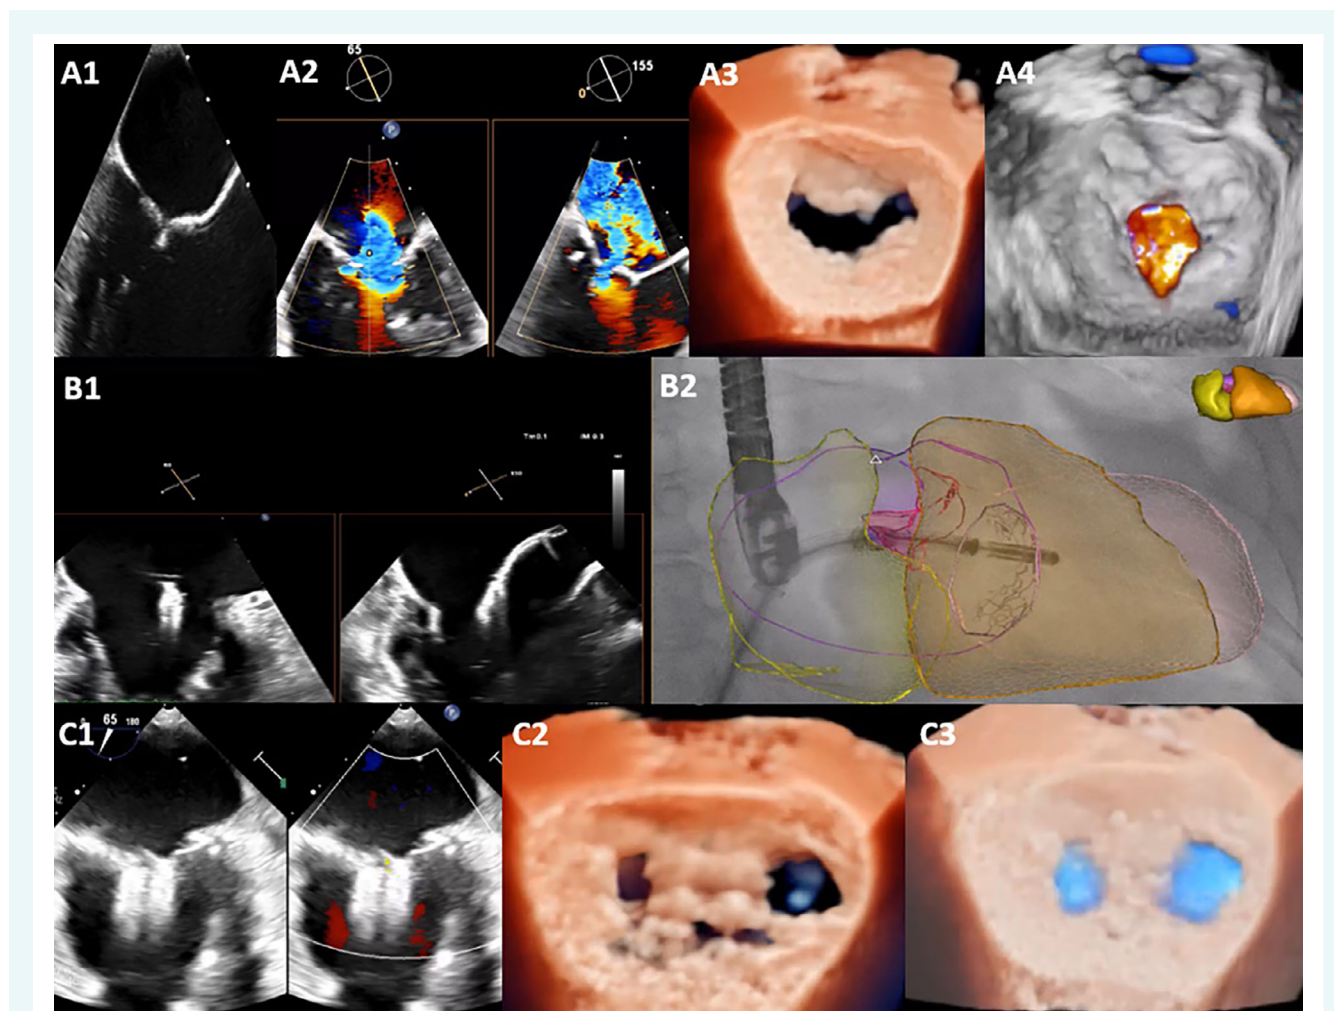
Contribution of imaging before and during transcatheter mitral valve edge-to-edge repair. Severe functional mitral regurgitation with leaflet tethering and a predominantly central jet, assessed by transoesophageal echocardiography (A1), including biplane (A2) and three-dimensional views with and without colour Doppler (A3 and A4). Procedural guiding during transcatheter mitral valve edge-to-edge repair using live biplane transoesophageal views (B1) in addition to fluoroscopy with fusion imaging (B2). Immediate post-procedural result after implantation of two MitraClip devices at the A2/P2 (central) level assessed by transoesophageal echocardiography (C1), including three-dimensional views with and without colour Doppler (C2 and C3).
